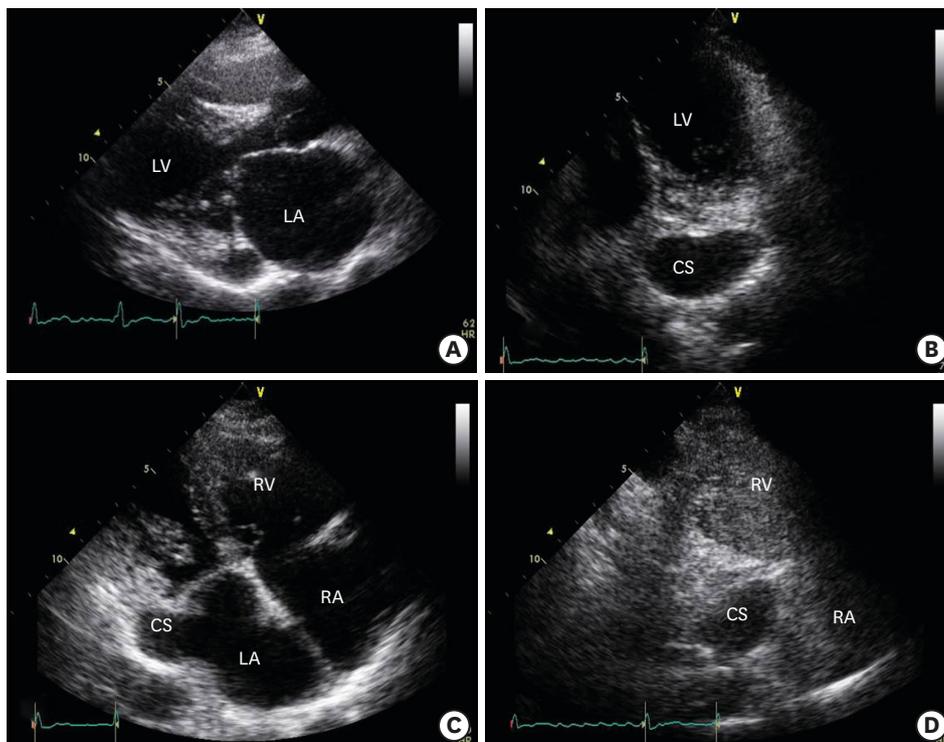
Transthoracic echocardiography revealed mitral stenosis and unroofed coronary sinus. (A) Doming of the anterior mitral leaflet and limited motion of the posterior mitral leaflet were demonstrated. (B) In the apical 4-chamber view with tilting, a huge dilated CS was identified. (C) With counterclockwise rotation of the probe, a 22-mm large defect between the dilated CS and the LA was detected. (D) Agitated saline was injected via the left antecubital vein. On contrast echocardiography, the RA was filled with air bubbles, but not the dilated CS, and then the right ventricle was filled with air bubbles later. This finding showed no persistent left superior vena cava. There was no negative jet in the RA, which raised the possibility of CS orifice atresia. CS: coronary sinus, LA: left atrium, LV: left ventricle, RA: right atrium, RV: right ventricle.
